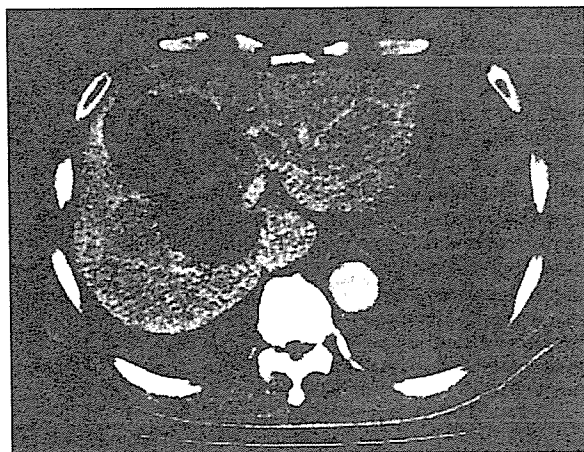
Upper abdominal contrast computed tomography. Regrowth of the cyst was noted 28 days after the initial drainage, for which a second drainage was performed.
